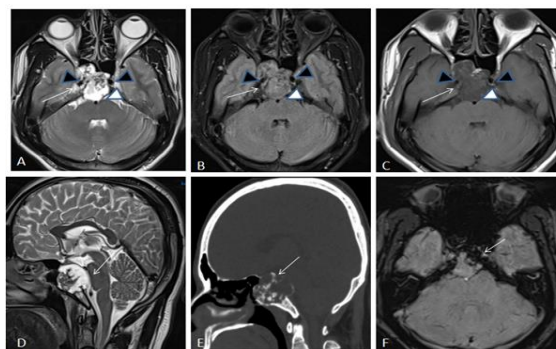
(A, B, C) Axial T2W, FLAIR, T1W sequence showing well-defined extra axial heterogeneously hyperintense lesion epicentered in the basi-sphenoid and clivus bone (more on the right side) extending
